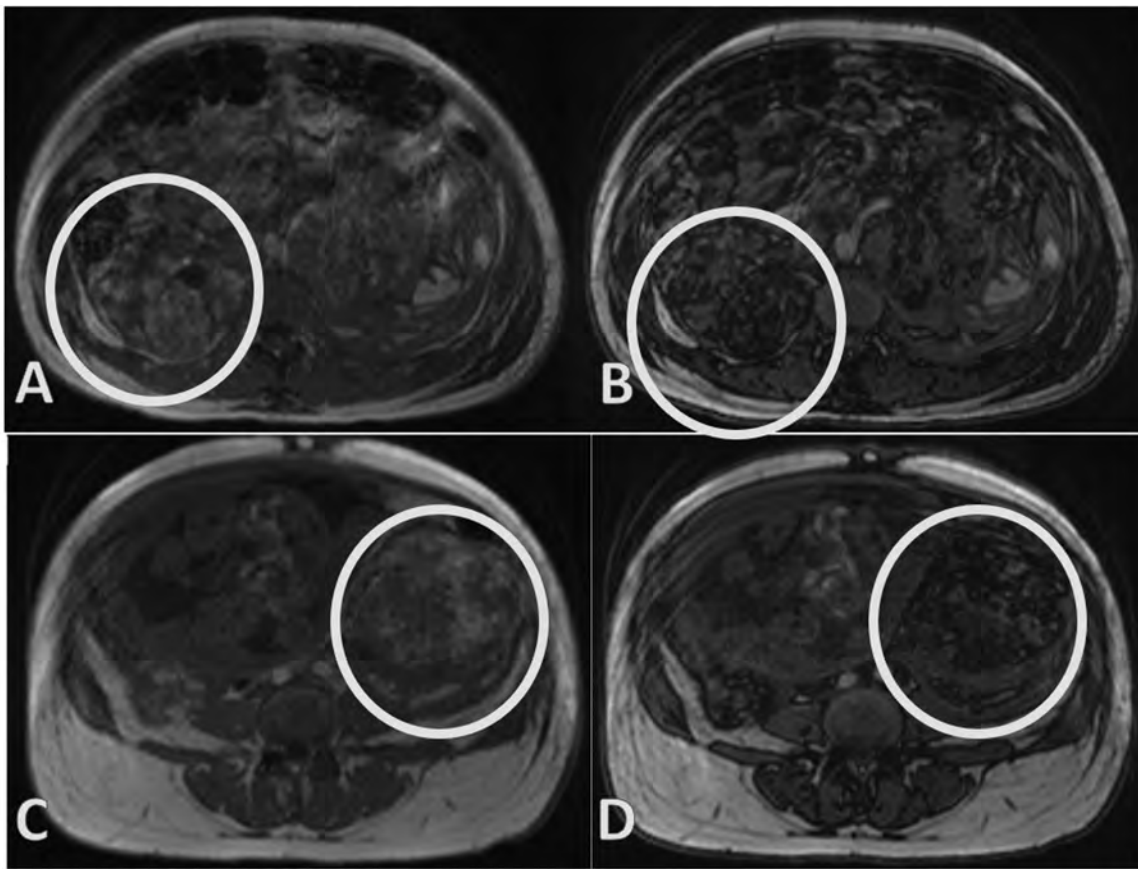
Contrast-enhanced magnetic resonance imaging of the abdomen (Dual Gradient Echo Sequence). A. Right Angiomyolipoma (In Phase); B. Right Angiomyolipoma; C. Left Angiomyolipoma (In Phase); D. Left Angiomyolipoma (Out Phase). Note the Fat Signal Drop on the Out Phase.
